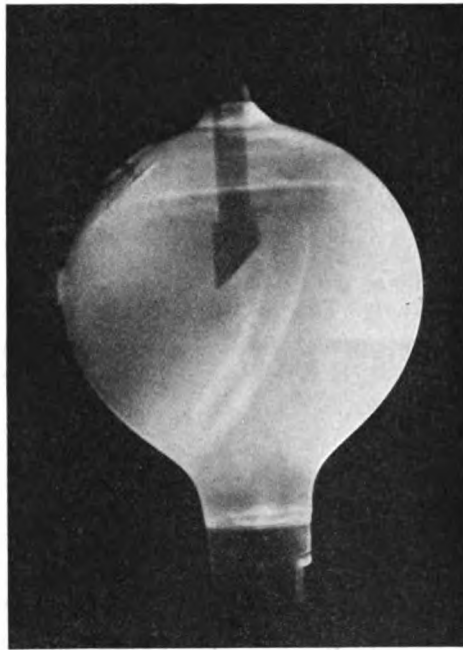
X-ray tube not showing a good "line" of demarcation.
